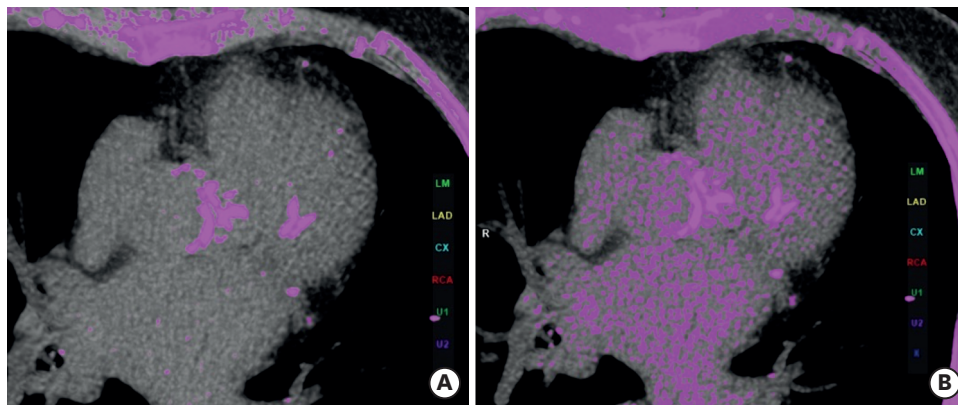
Effect of CT threshold on CAC score calculation. The threshold in (A) is set at 130 HU and in (B) at 110 HU. Lowering the threshold by 20 HU leads to a significant increase in image noise, which can alter the final score. CT: computed tomography, HU: Hounsfield units, CAC: coronary artery calcium, LM: left main, LAD: left anterior descending, Cx: circumflex artery, RCA: right coronary artery.
